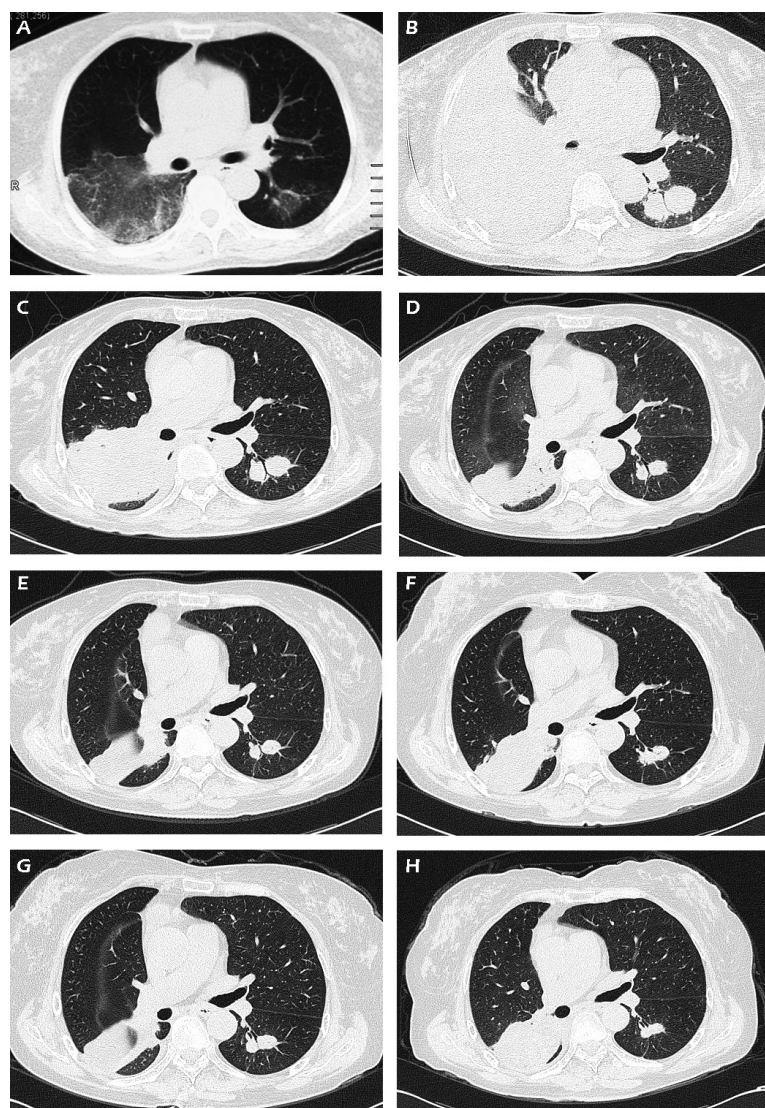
Thoracic computed tomography (CT) scans findings. A, on the 5th day after surgery, thoracic CT showed bilateral ground glass opacities. B, on admission to our hospital, thoracic HRCT demonstrated a large consolidation in the right lower lobe and multiple nodules in the left lower lobe. C, on the 21st day of the steroids treatment (MP 80 mg bid \times 5d, MP 40 mg qd \times 16d, indomethacin 6.25 mg bid \times 2w), thoracic HRCT showed an obvious resolution (comparing to those on admission). D, in week 11 of the steroids treatment (MP 80 mg bid \times 5d, MP 40 mg qd \times 6w, MP 20 mg qd \times 4w, indomethacin 6.25 mg bid \times 10w), thoracic HRCT showed a small resolution (comparing to those in 21st day). E, in week 17 of the steroids treatment (MP 80 mg bid \times 5d, MP 40 mg qd \times 6w, MP 20 mg qd \times 10w, indomethacin 6.25 mg bid \times 16w), thoracic HRCT showed similar lesions (comparing to those in week 11). F, in week 25 of the steroids treatment (MP 80 mg bid \times 5d, MP 40 mg qd \times 6w, MP 20 mg qd \times 10w, MP 16 mg qd \times 4w, MP 12 mg qd \times 4w, indomethacin 6.25 mg bid \times 24w), thoracic HRCT showed similar lesions (comparing to those in week 11). G, after 3 months of steroids withdrawal, thoracic HRCT showed similar lesions (comparing to those in week 11). H, after 1 year of steroids withdrawal on June 1st, 2015, thoracic HRCT showed similar lesions (comparing to those in week 11).
